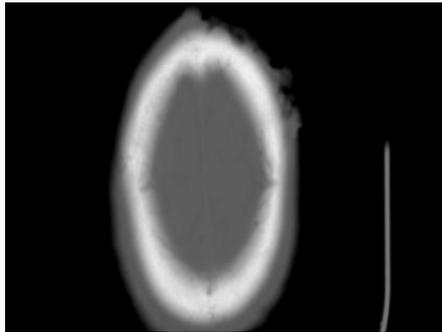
CT Showing soft tissue density lesion with normal bone.
